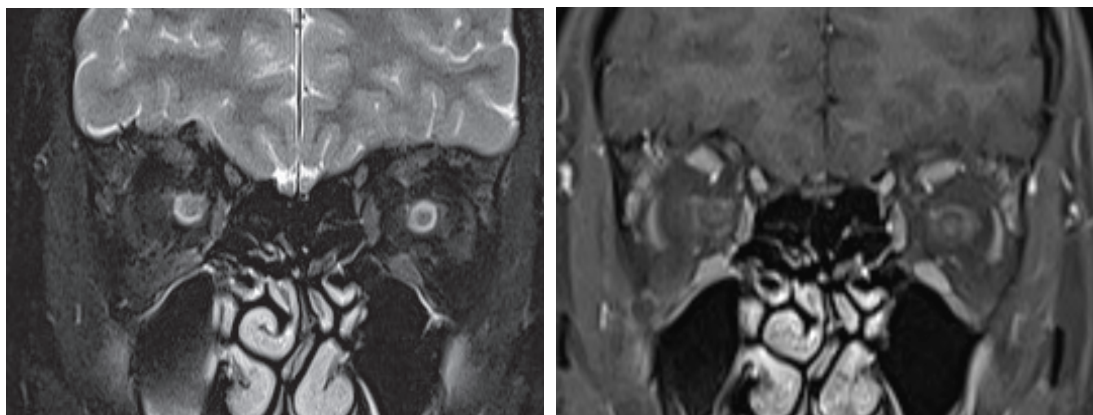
Coronal T2-weighted image of the orbits showing the 'doughnut sign' of fluid in the swollen optic nerve sheath suggestive of perineural sheath inflammation (right). The coronal T1 fat suppressed contrast enhanced image shows the perineural sheath enhancement (left).
